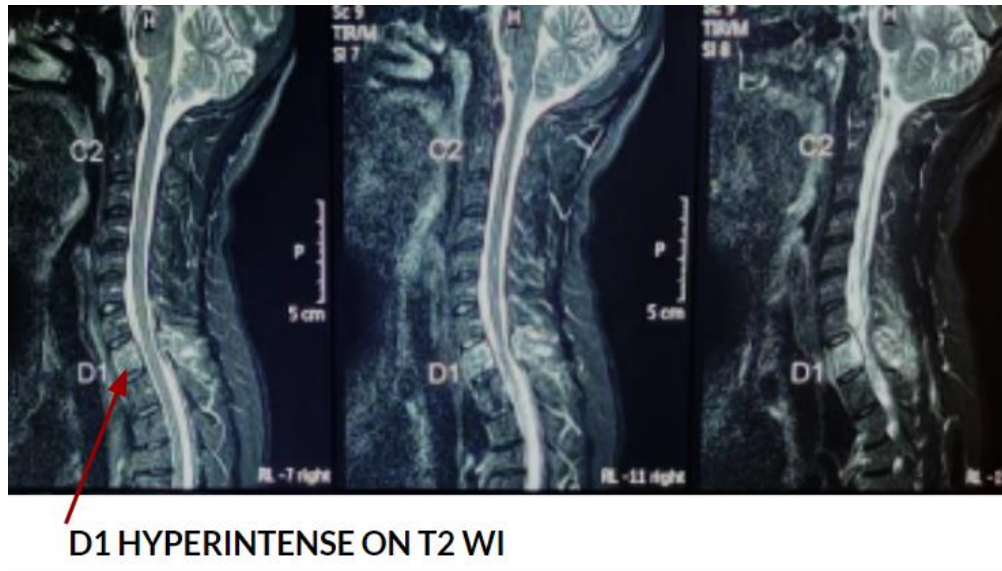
MRI cervical spine sagittal sections which show a hyperintense lesion of the first thoracic vertebrae in T2 weighted images.
